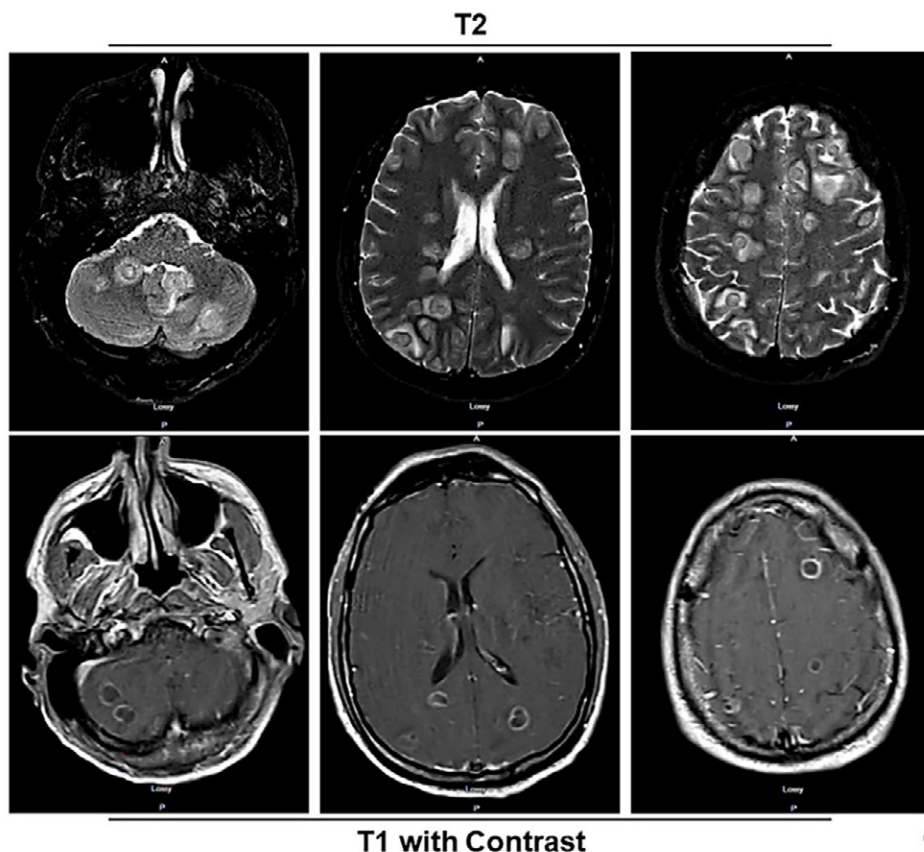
MRI of a 34-year-old patient with diffuse ring-enhancing lesions of the brain. T2 weighted (top) and T1 with contrast (bottom) MRI images of septic emboli to the brain.
